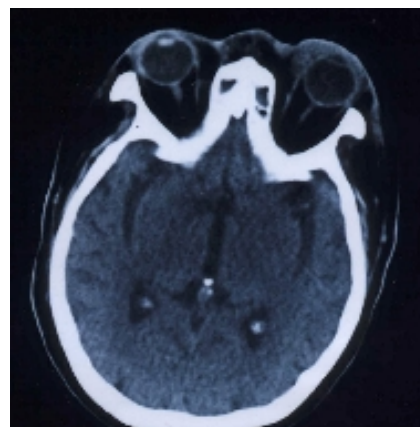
CT scan showing left orbital fat thickness with exophthalmus
